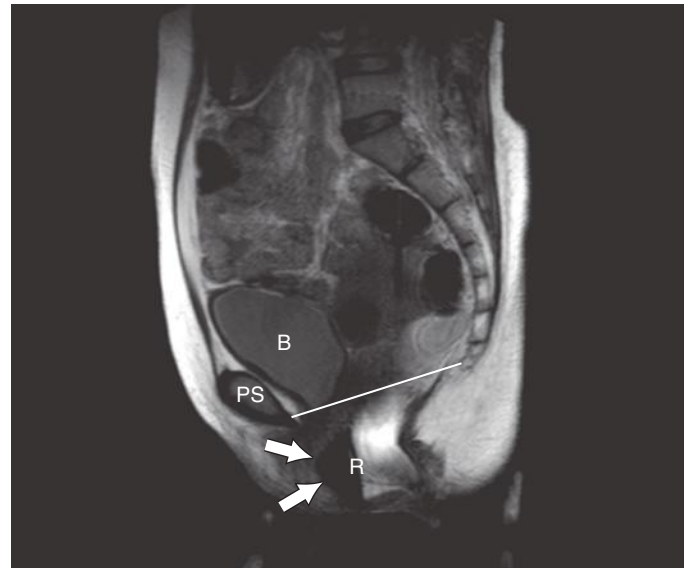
Rectocele during strain sagittal magnetic resonance imaging (MRI). Sagittal T2-weighted MRI obtained during strain shows abnormal anterior bulge of the anterior wall of the rectum greater than 2 cm from the midaxis of the anal canal (*arrows*). B, bladder; PS, pubic symphysis; R, rectum.
